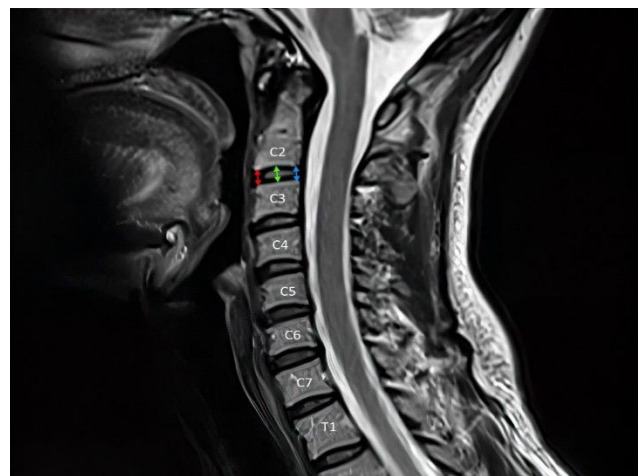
Sagittal T2- weighted MRI image of the cervical spine. The red arrow represents IVD-AH. The green arrow represents IVD-MH. The blue arrow represents IVD-PH.
